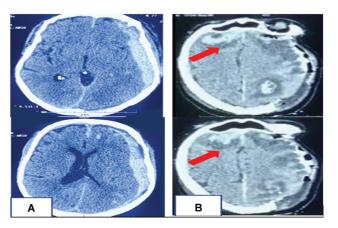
(A) Preoperative computed tomography (CT) scan images suggestive of thick left frontotemporoparietal subdural hematoma with midline shift. (B) Postoperative CT scan images are suggestive of evacuation of the left subdural hematoma with blossoming of the right frontal contusion along with surrounding edema (*red arrow*).
